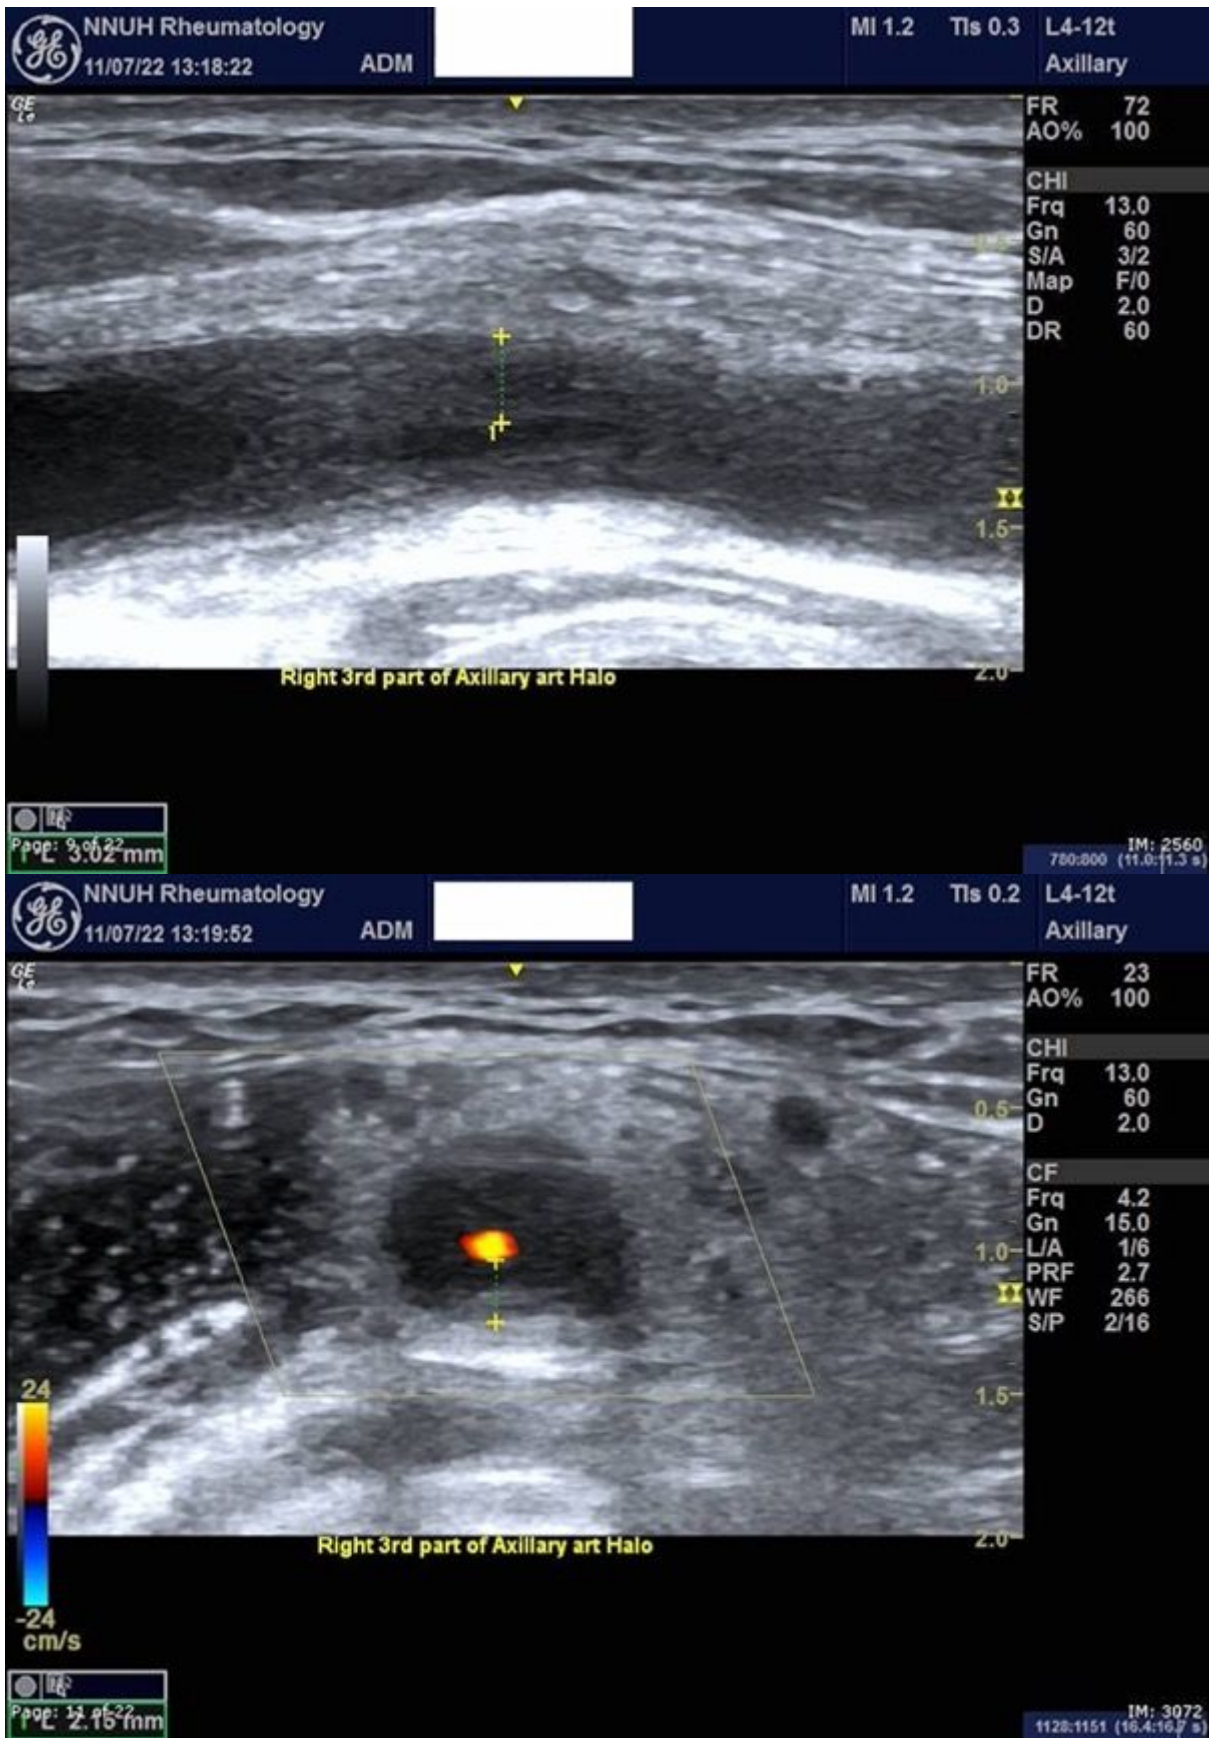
Ultrasonographic image of the right axillary artery acquired using a GE LOGIQ e machine with a linear 4-12 MHz probe
